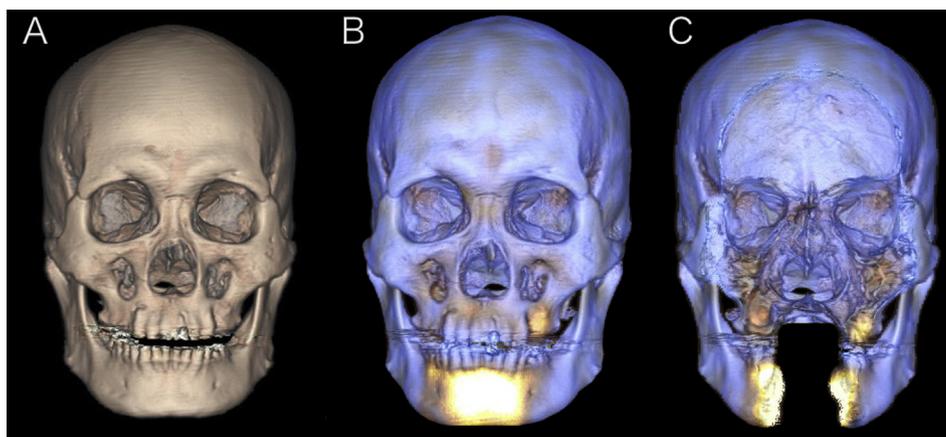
Generation of 3D SPECT/CT images of a patient with jaw bone invasion (JBI) due to carcinoma of the floor of the mouth. Conventional 3D volume-rendering CT images (A) were first generated, and radioisotope uptake in the bones including the jaw bone was then displayed onto them according to the SPECT value (B). The yellow arrow indicates the hypermetabolic change caused by JBI, whereas the white arrowhead indicates periodontitis. The 3D data images can be arbitrarily cut to see cross-sectional images (C).
